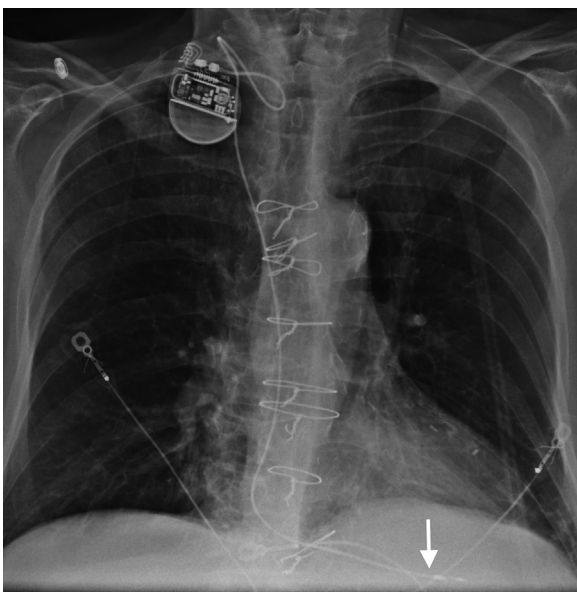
Chest radiograph demonstrating a pacemaker with a single lead in the right ventricle. This likely is a temporary transvenous pacemaker given the position of the generator and venous access (ie, right internal jugular).
